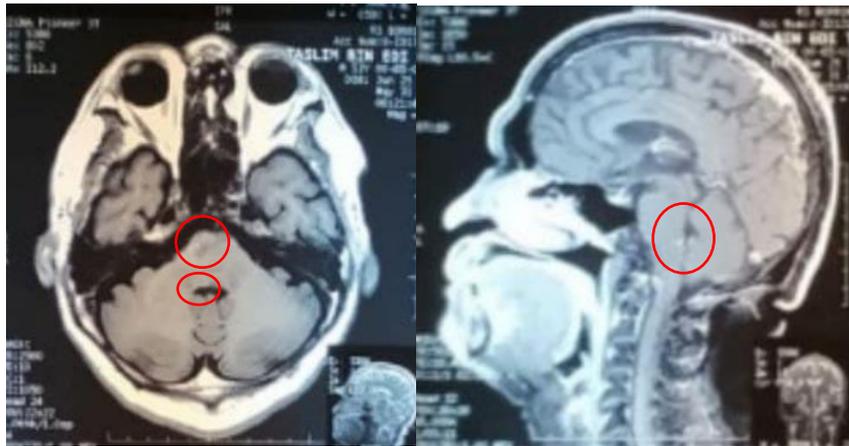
MRI findings support diagnostic criteria for multiple sclerosis. Note the hyperintense area (red circle).
